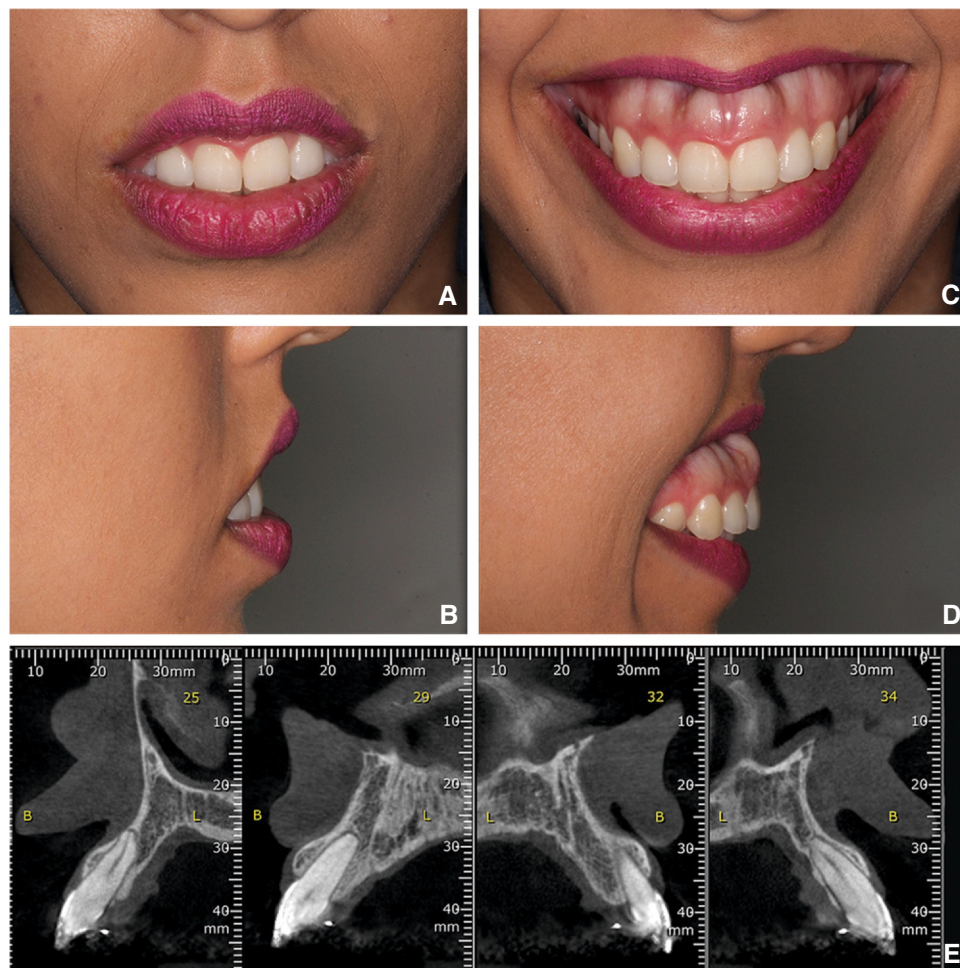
Patient 1. A, Initial frontal view at rest. B, Initial profile view at rest. C, Frontal smile view showing excessive gingival display and presence of buccal maxillary exostoses. D, Profile smile view. E, Detail of cone beam computed tomography image of maxillary anterior teeth (from left to right, respectively) demonstrating prominent maxillary exostoses.
